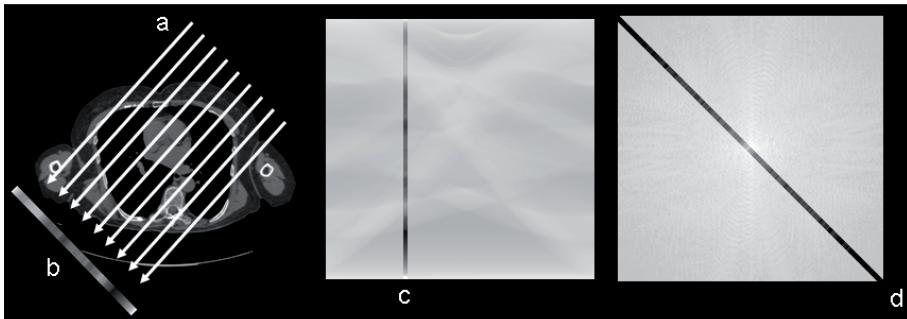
Projection (b) recorded by the CT scanner for (a); one specific projection angle corresponds to one line in Radon space (c) and a 1-D FT of the recorded line in the sinogram yields one line in Fourier space (d) at the same angle.
